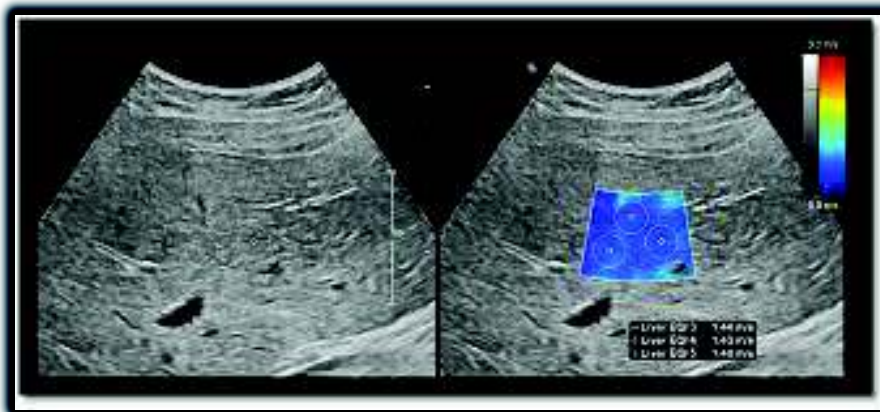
Examples of ultrasound images
